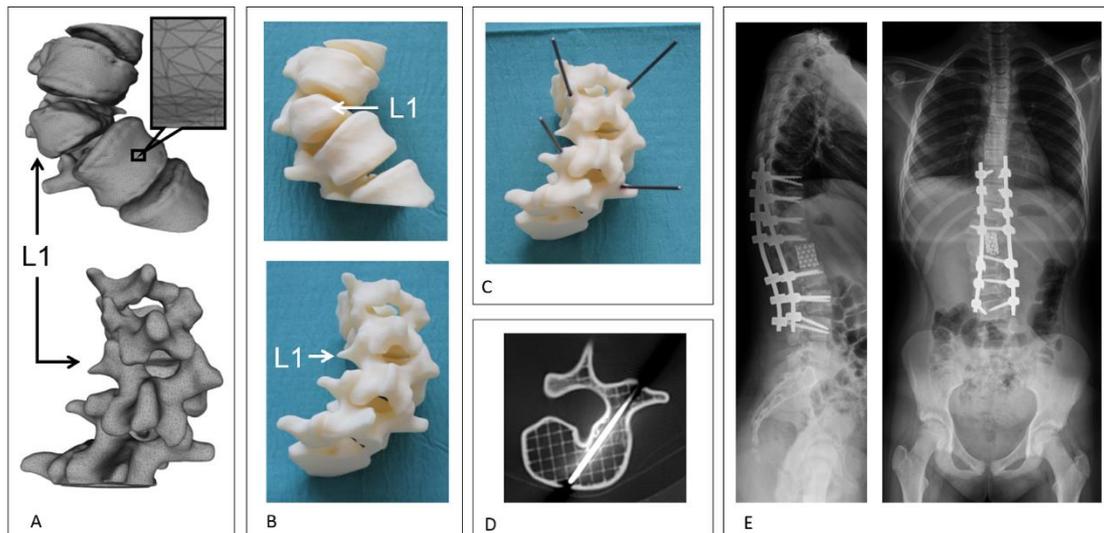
Application of the FDM 3D printed model in the surgical planning process in congenital scoliosis. A, The segmented 3D geometry (triangulated surface mesh) of the thoraco-lumbar junction (L1 hemivertebra) in anterior and posterior view. B, 3D printed physical model of the same thoraco-lumbar section as in A. C Titanium rods were introduced in the pedicle, in the optimal axis of the screw insertion, as planned for the surgery. D Internal grid structure of the FDM model with the inserted titanium rod (axial CT scan). E Post-operative standing X-rays shows the screws (correction and stabilization from T9 to L4 with Mesh cage) inserted in the correct position, helped by the visual guidance provided by the rods inserted in the physical model.
